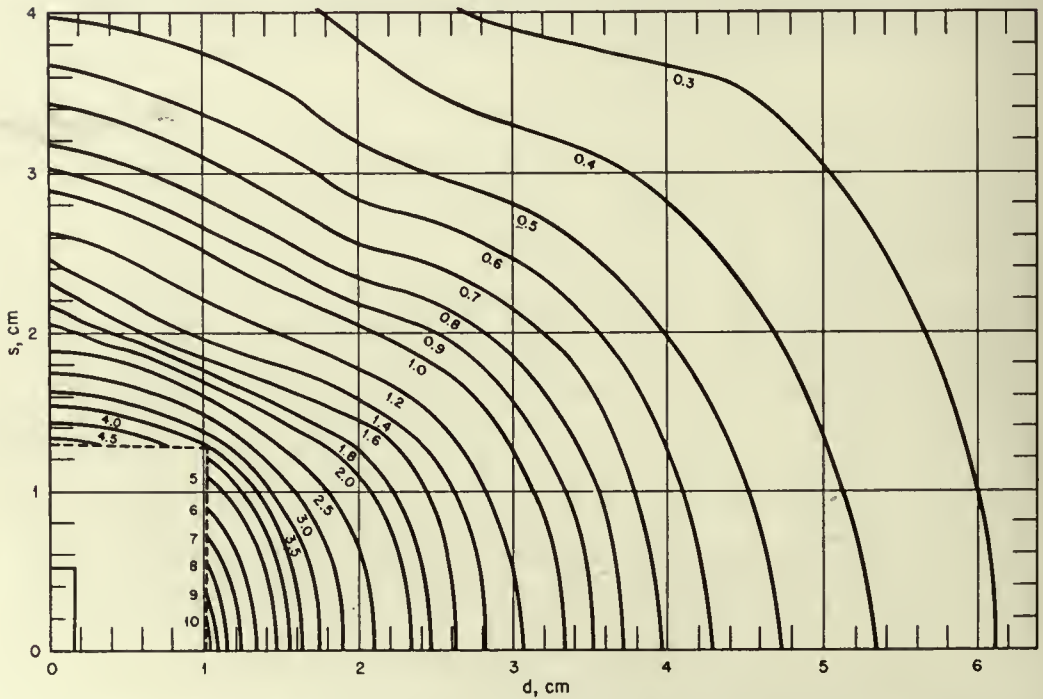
Isodose curves for the colpostat capsular sources shown in Fig. 3. Rates are given in roentgens per millicurie-hour.
